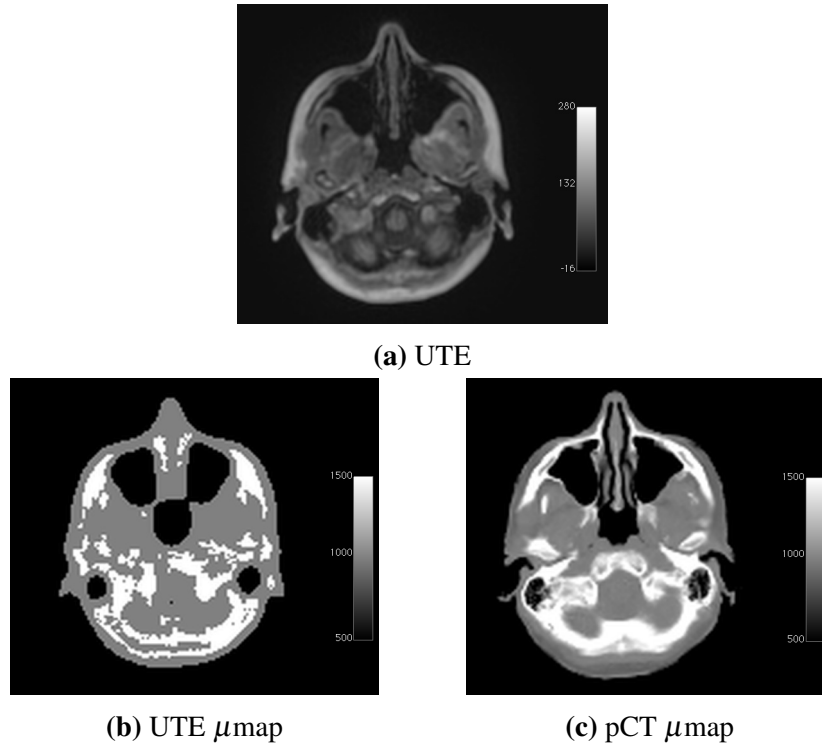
Axial slice of a brain image acquired using a UTE sequence (a) is shown with attenuation maps derived using the UTE image (b) and derived from a pseudo CT image based on an atlas-based method [Burgos et al., 2014]
